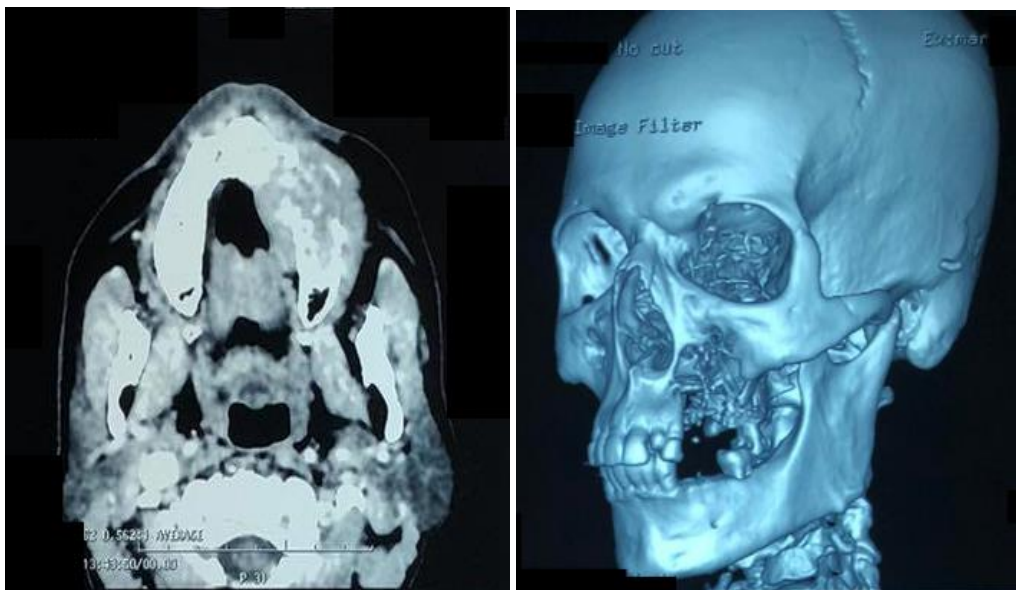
Naso-sinus CT showing a lytic tumoral process centered on the floor of the left maxillary sinus
